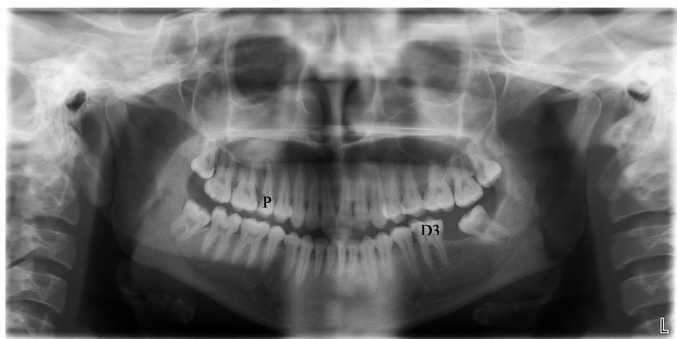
Panoramic Radiograph showing scoring
